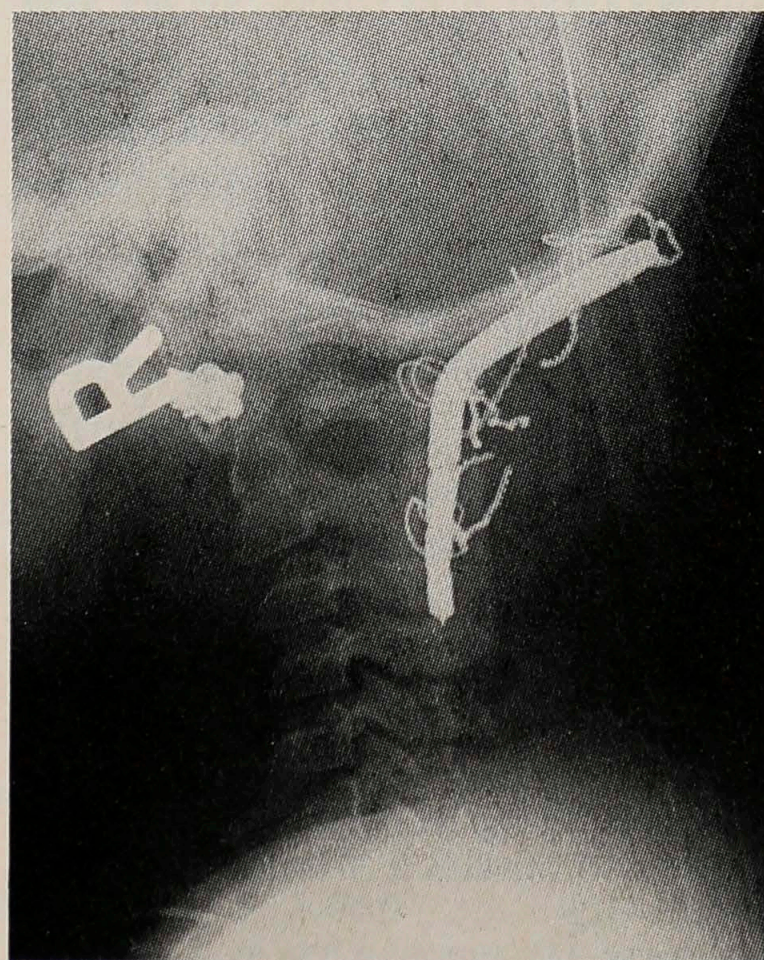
Patient 5. Lateral cervical spine x-ray film 4.6 months postoperatively, showing occiput-to-C2 fusion with combination of Luque rod and autogeneic bone.
